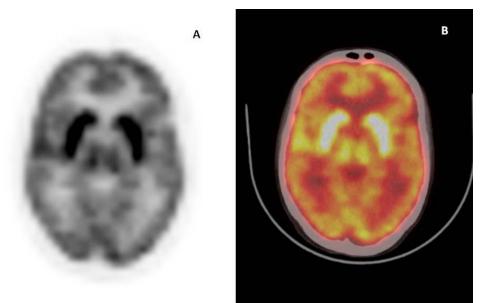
Third 18-FDG PET scan for treatment evaluation (PET alone on the left and brain-centered PET/CT fusion image in axial slice on the right). Cortical uptake of the glucose analogue continues to decrease.
